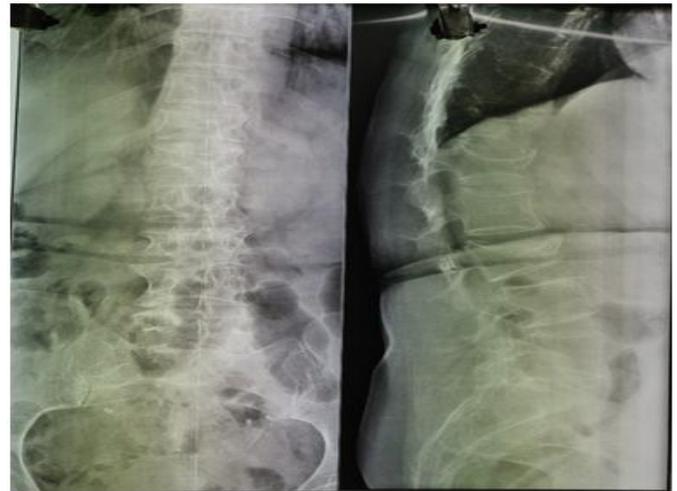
X-Ray L-S spine AP and LATERAL
